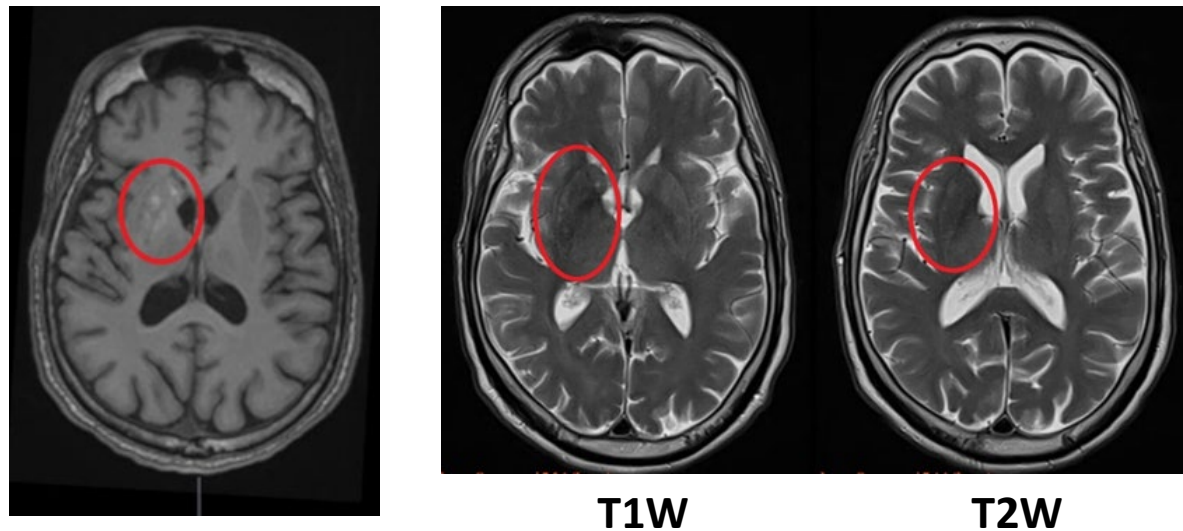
Plain Cranial MRI of the patient showing T1W hyperintense, T2W hypointense involving the right putamen, globus pallidus, and caudate nucleus, seen in cases of diabetic hyperglycemia
